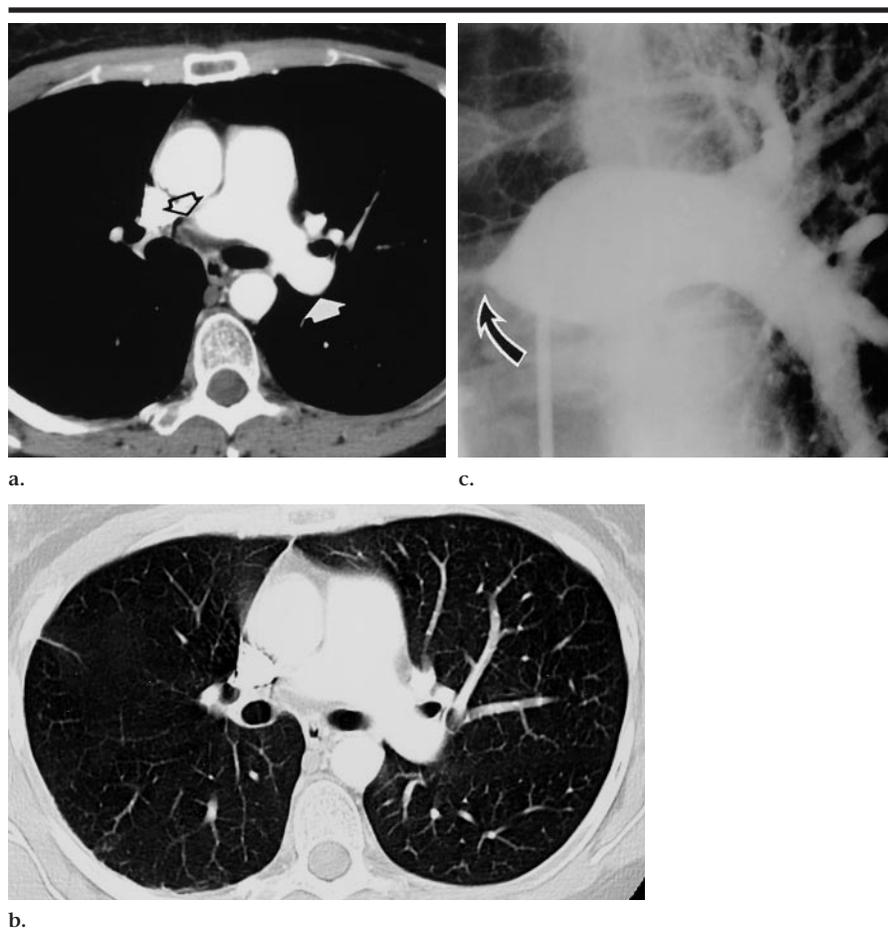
Pulmonary arteritis in a 43-year-old woman. (a) Transverse CT angiogram shows tapering of the right pulmonary artery (open arrow) and a normal left pulmonary artery (solid arrow). (b) Transverse CT angiogram obtained with lung windows shows decreased size of vessels in the right middle and right upper lobes. Vessel size and perfusion on the left are normal. (c) Anteroposterior conventional angiogram shows abrupt tapering of the right pulmonary artery (arrow) and normal arteries in the left lung.
